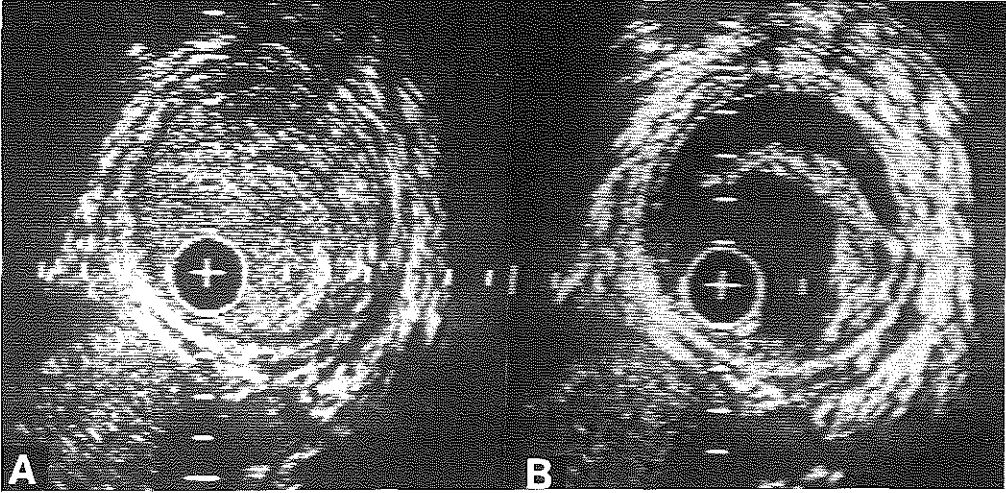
Intravascular ultrasonic cross-sections of the superficial femoral artery (30 MHz) obtained *in vivo* showing the advantage of saline injection for off-line analysis of still-frames. A, echogenicity of blood hampers delineation of the lumen contour. B, dissection became evident following injection of saline. Calibration = 1 mm.
